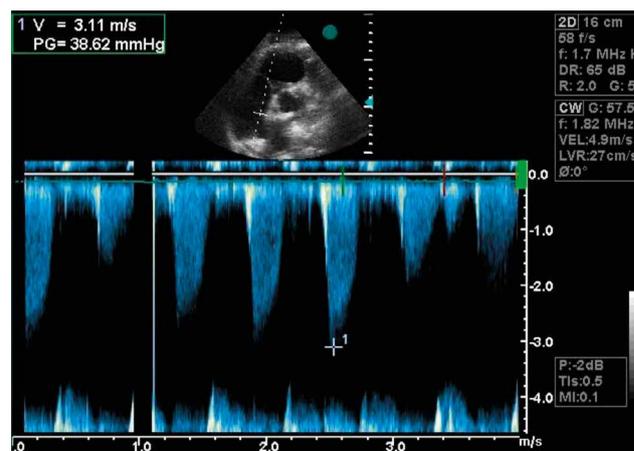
The transthoracic echocardiogram shows the ruptured tricuspid valve causing severe tricuspid regurgitation, with jet flow velocities of around 3.0 m/s, and with a pressure gradient of 38 mmHg, indicating pulmonary hypertension
